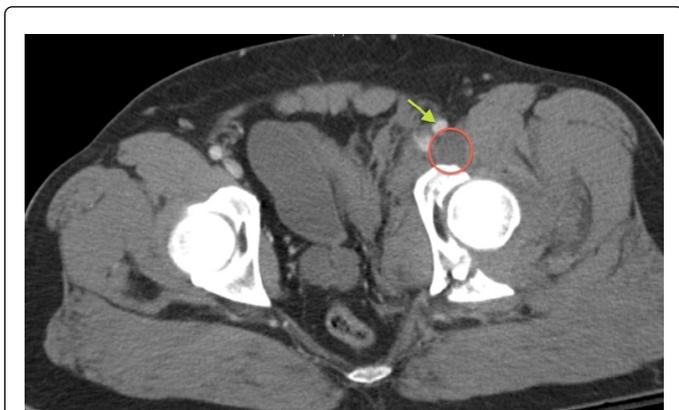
Axial soft tissue window of preoperative CT scan demonstrating mass just lateral to femoral vessels. Green arrow demonstrates femoral artery. Cystic mass demonstrated inside red circle.
